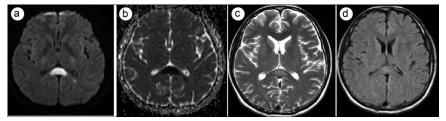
(a) Diffusion-weighted imaging and (b) apparent diffusion coefficient images show the splenium of the corpus callosum compatible with cytotoxic edema. (c) Axial T2 and (d) axial FLAIR sequences show a hyperintense lesion.
